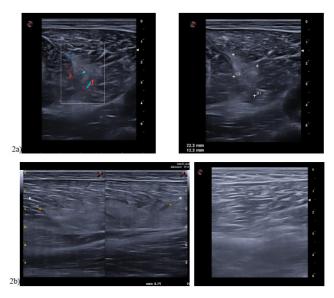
Objective ultrasound evaluation of an acute lesion of tight flexors before (a) and after (b) supplementation, example 1
